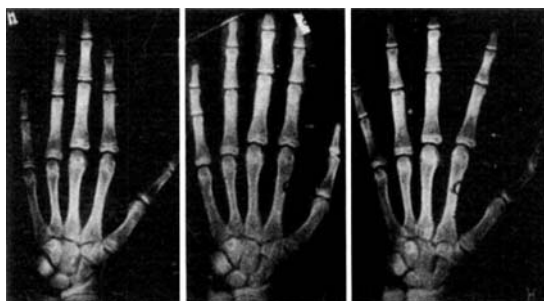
X-rays of the hand and wrist of a boy at the ages of 17⁵, 18⁶, and 19² years. The delay in skeletal development amounts to 3⁰, 3⁶, and 3⁵ years respectively. Slipping of the upper femoral epiphysis was diagnosed at 17⁵ years of age (Case 8).
